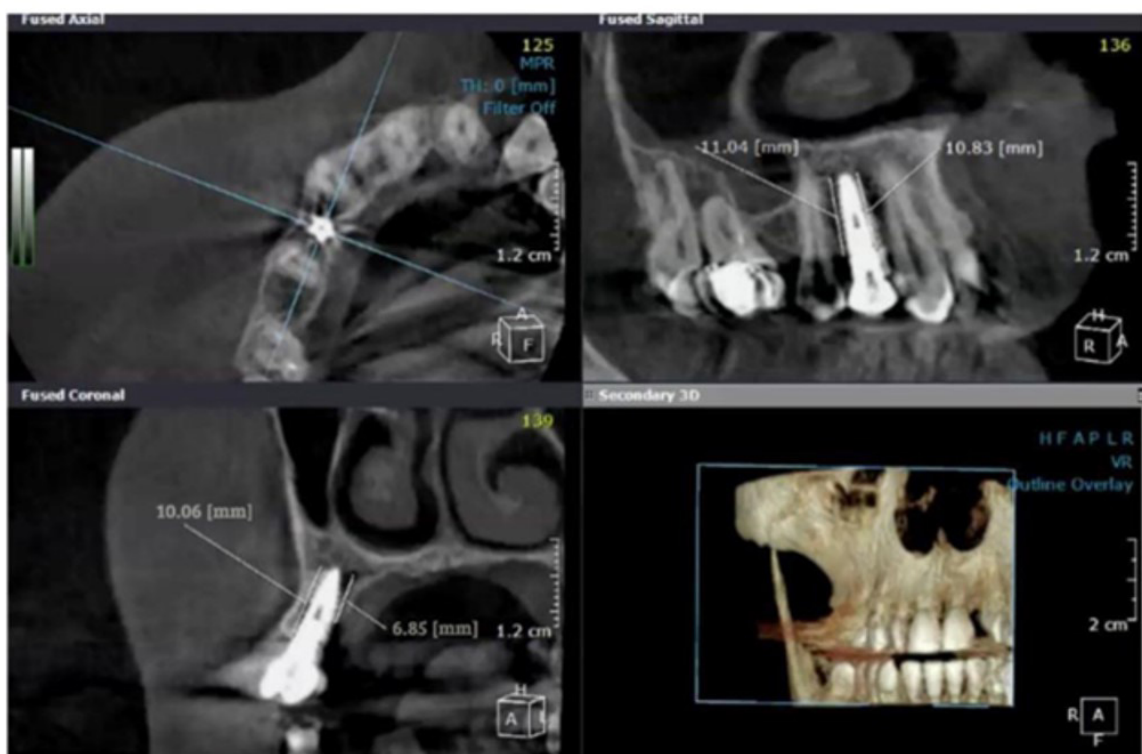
Buccal, palatal, mesial, and distal CBCT measurements at 12 months.
